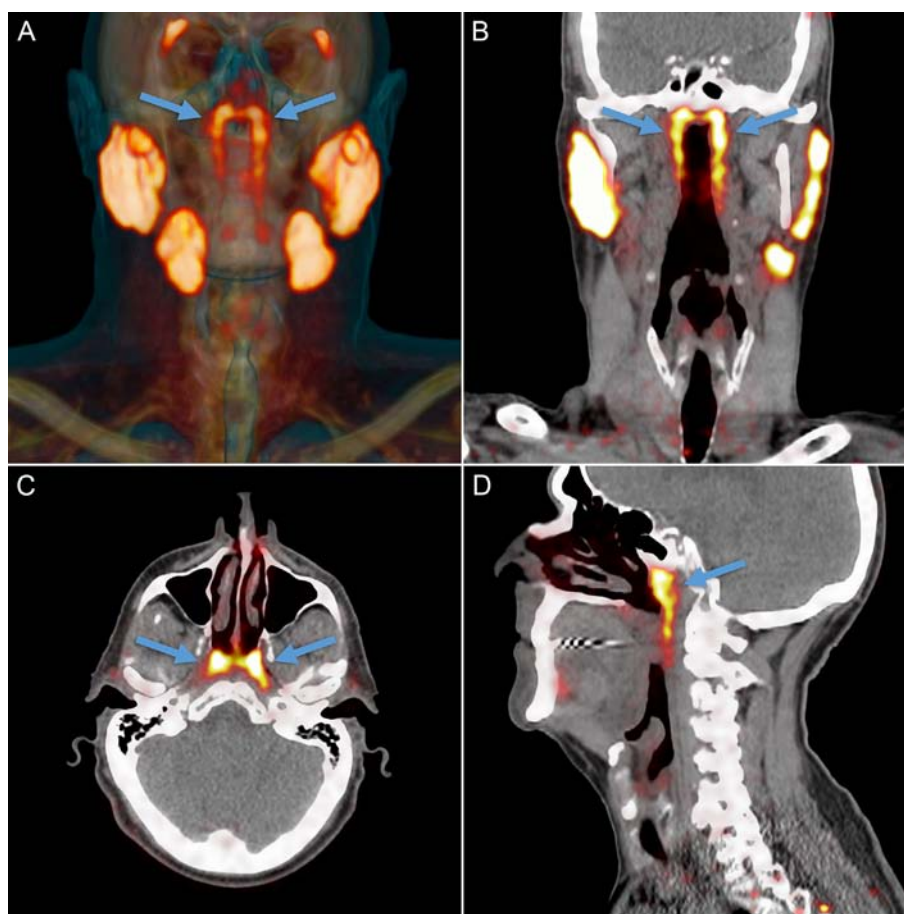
Projections of PSMA PET/CT. Overview of the salivary gland tissues as seen on PSMA PET/CT. PSMA PET projected as orange signal on reference CT. The known major salivary glands, which include the parotid, submandibular and sublingual glands, all abundantly express PSMA. An unknown structure in the nasopharynx showed similar imaging characteristics (arrows). A 3-dimensional representation of the PSMA PET/CT scan is shown in Video 1 in the Supplementary material. Location and extent of the tubarial glands in a random patient. Shown are coronal (B), axial (C) and sagittal (D) slices at the level of the torus tubarius, of PSMA PET projected as yellow signal on grayscale CT. The glandular structure is visible as PSMA-positive tissue (arrows). The coronal slices also show some parts of the parotid and submandibular glands, which demonstrate similar imaging characteristics.
